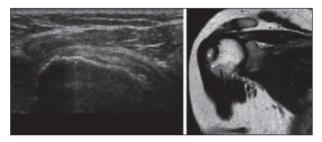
Ultrasound evaluation at 6 months and MRI evaluation at 24 months group B.
